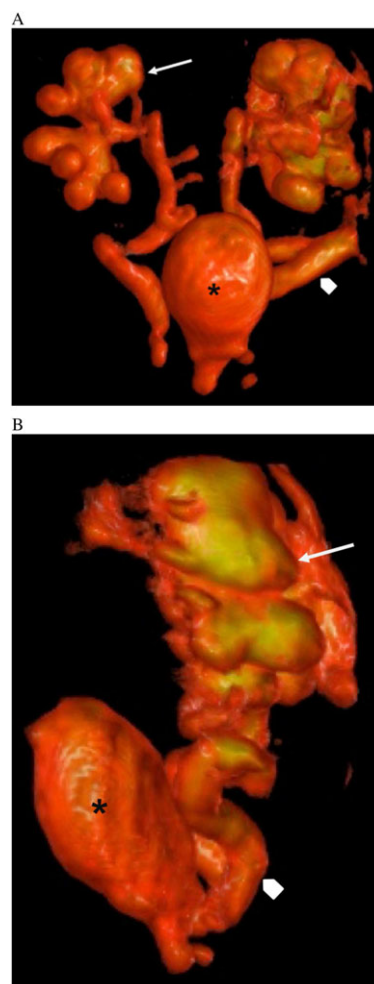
Three-dimensional virtual reconstruction of fetal urinary tract (31 weeks of gestation) from magnetic resonance imaging scan data at (A) coronal and (B) sagittal views showing the increased bladder volume (*), dilated ureters (head arrow), and hydronephrosis (arrow)
